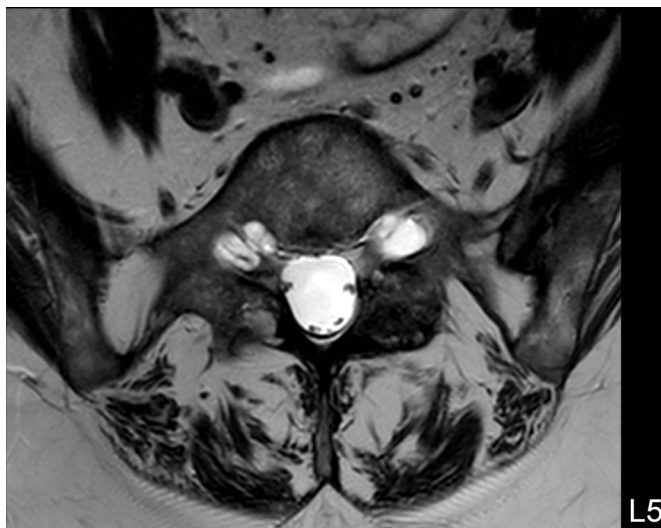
MRI Axial cut at L5 Level.
